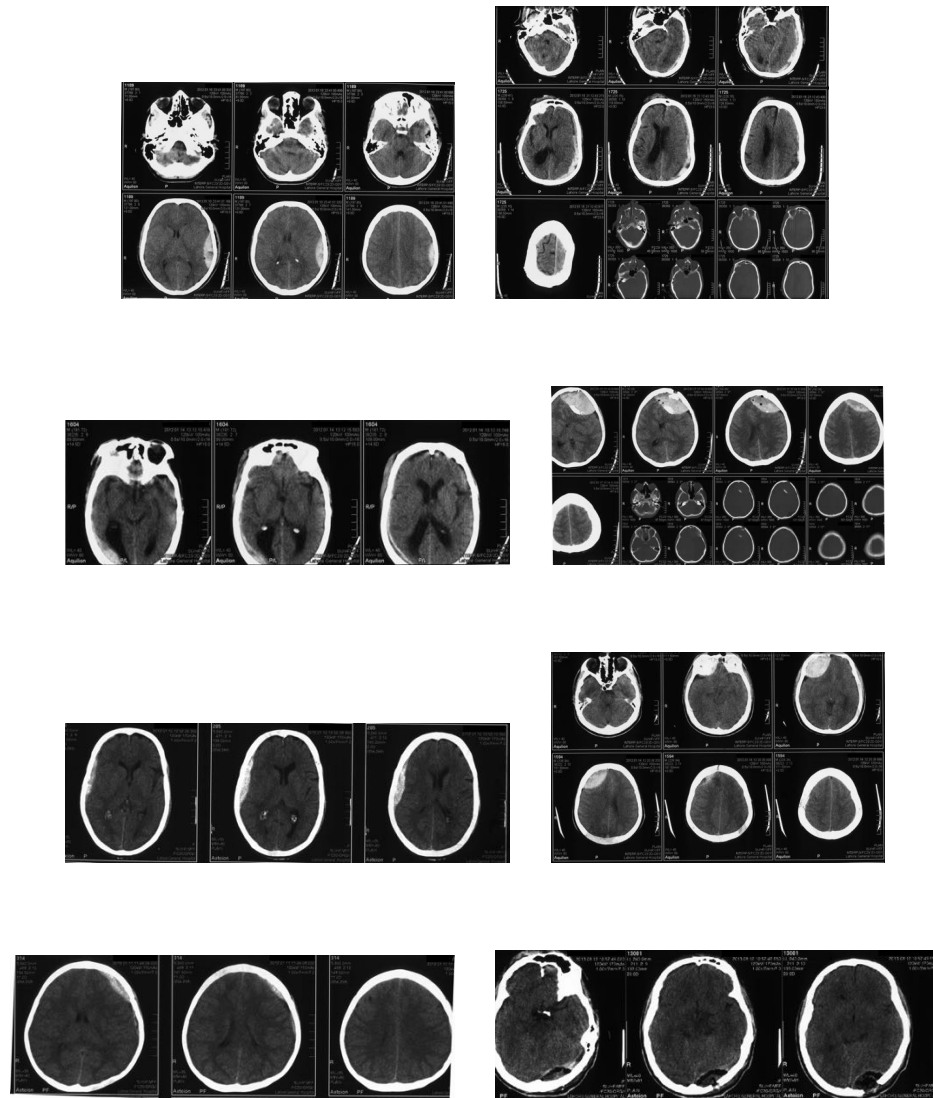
CT scans of the TBI Patients used in experiments. Only a few cases are given to establish reference.
